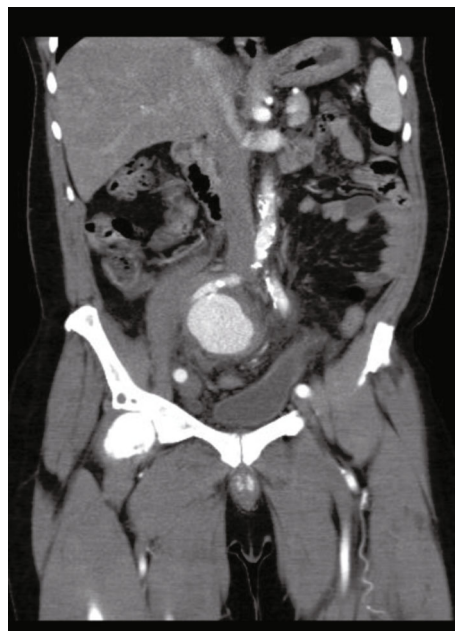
Contrast-enhanced CT scan of the abdomen and pelvis, with coronal images showing a large contrast-filled structure in keeping with iliac artery aneurysm compressing and pushing the urinary bladder laterally.
